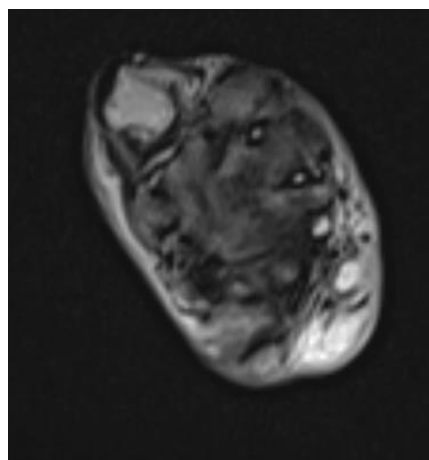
Axial T2-weighted MRI sequence showing the heterogeneous signal of the mass with alternating areas of moderate and low signal intensity (asterisk), consistent with fibrous tissue content interspersed with cellular components, and enlargement of inter metatarsal spaces
